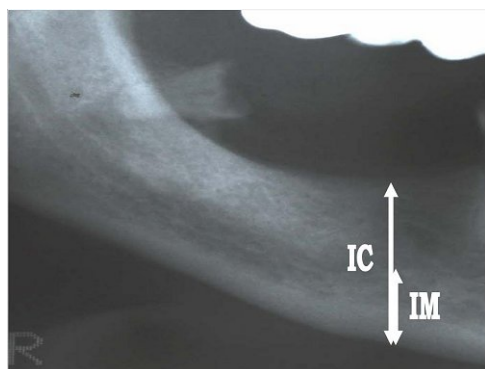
Measuring method for the height of ridge on panoramic radiograph - from the inferior border to the superior edge of the alveolar crest in the region of the mental foramen (IC), divided by the distance from the inferior border to the lower edge of the mental foramen (IM) to calculate the percent of bone remaining (Kribbs, 1990)
